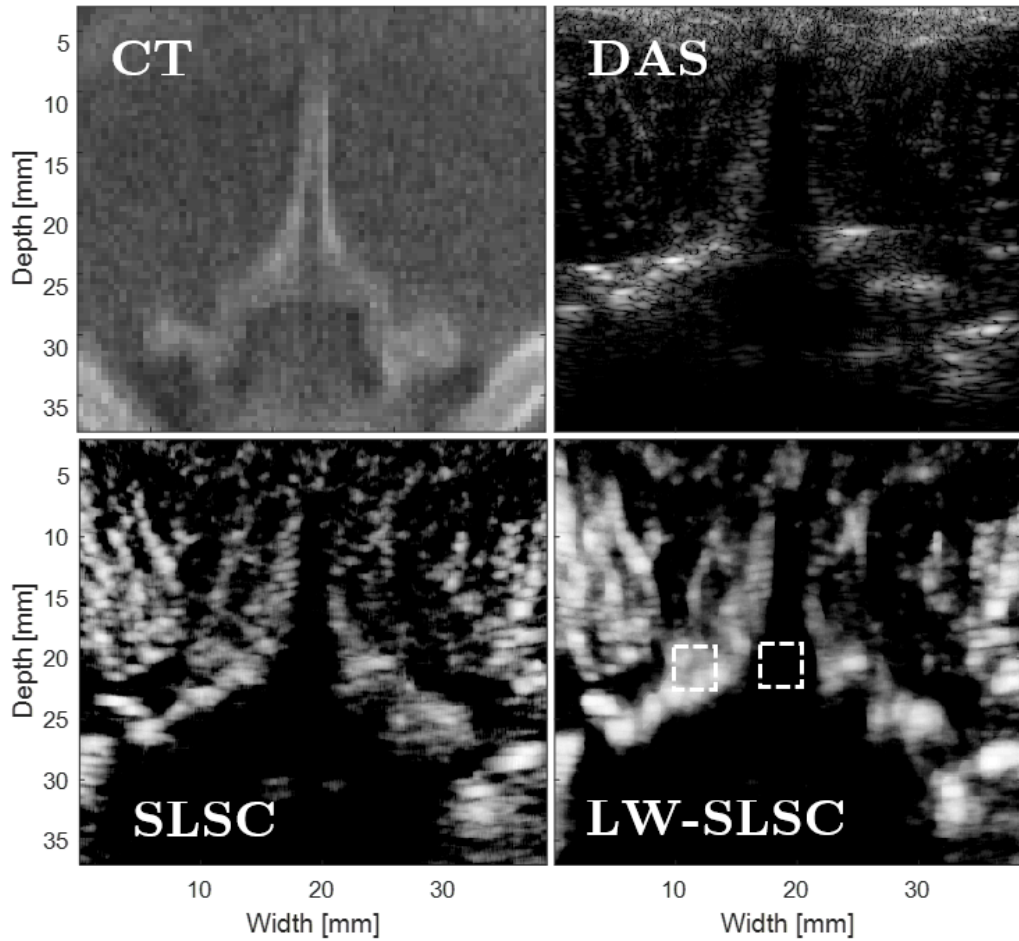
Examples of reconstructed CT, DAS, SLSC ($M = 9$) and LW-SLSC ($N_L = 28$, $\alpha=0.1$) images of the caprine sample (not registered). Regions selected for gCNR measurements are denoted by the dashed boxes.
